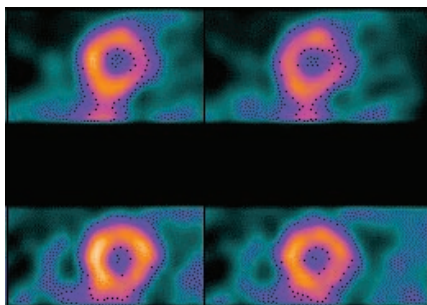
Thallium-201 single-photon emission computed tomography (SPECT) short-axis image, comparing rest study (top) with delayed study (bottom). There is a lateral defect on the rest images and comparative redistribution on the delayed images, implying viability of the lateral wall.
